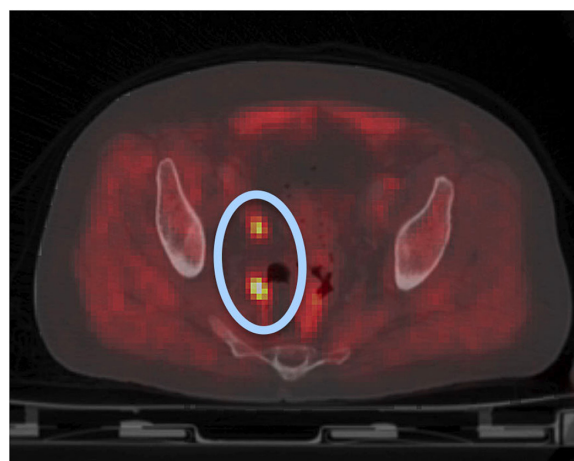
PET/CT image postprostatectomy depicting possible lymph node metastasis (blue oval with orange hot spots).
